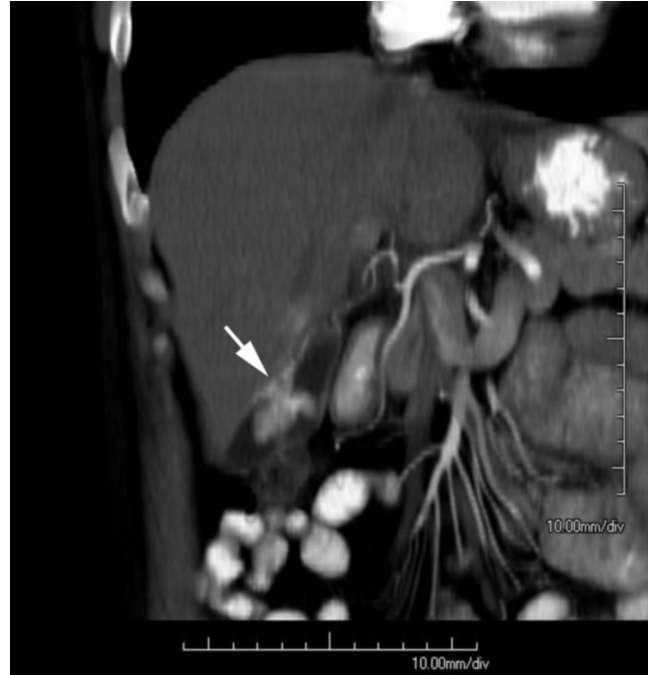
50-year-old man with renal-cell carcinoma. 3D CT reconstruction of gallbladder lesion with anomalous vascular supply derived from intrahepatic hepatic arterial branches (arrow).
